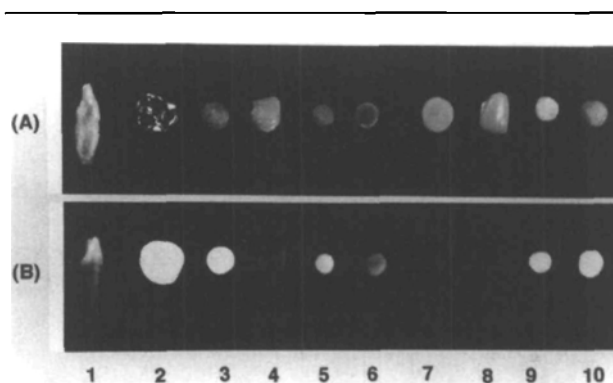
FIGURE Photograph (A) and X-ray (B) of teeth (1), metal (2), amalgam (3) porcelain (4), light curing resin (5), glass ionomer cement (6), self curing resin (7), temporary crown (8), temporary filling (9, 10).
